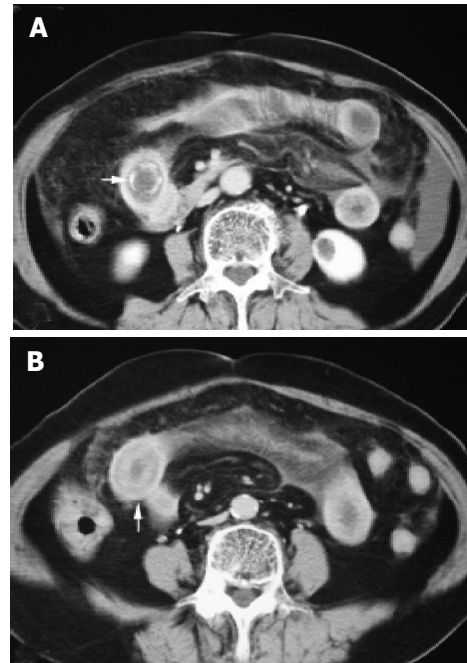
Axial contrast enhanced CT delineated wall thickening (between arrows) of duodenum second portion >1 cm (case 3).
